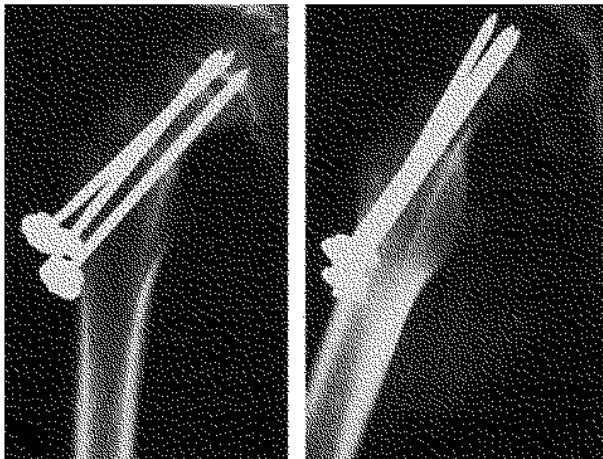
Postoperative radiographs showing the position of transfixing Moore pins in the slipped capital femoral epiphysis.
